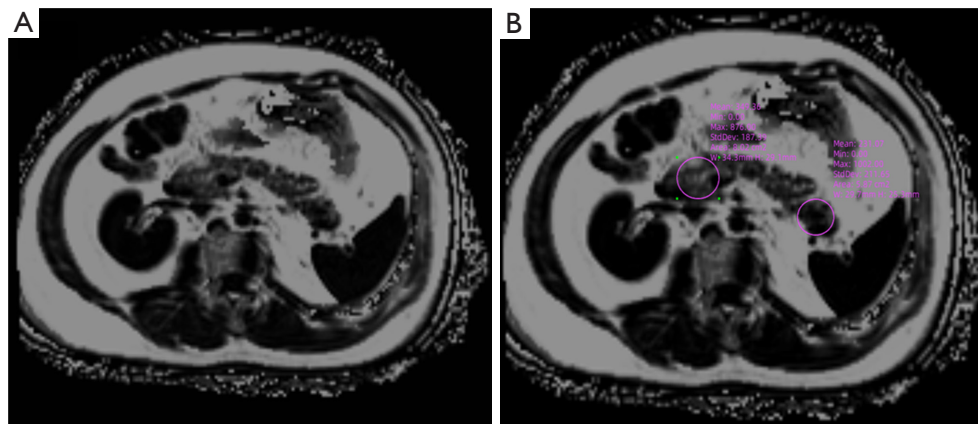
Magnetic resonance imaging shows the presence of fat infiltration in the pancreas. A patient with low (A) and high (B) amounts of pancreatic fat.
